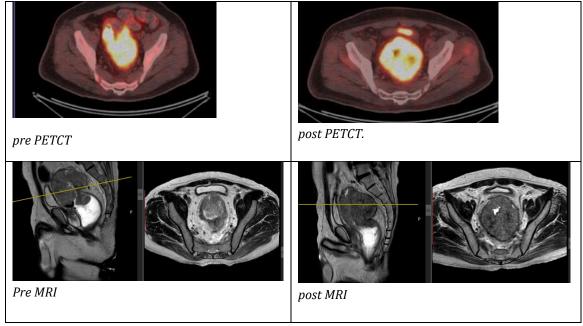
45 years old male patient with LARC, confirmed by PET/CT and MRI. Post NAT PET/CT and MRI showed PMD and PD using PERCIST and RECIST criteria respectively. Post operative pathology revealed extensive residual tumour
